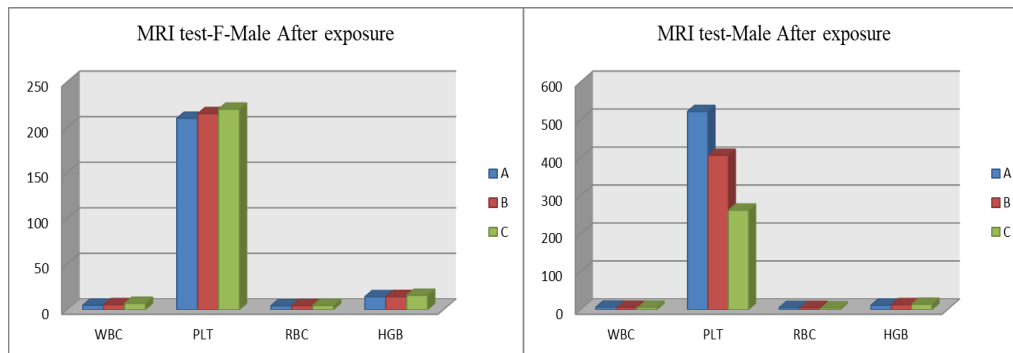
MRI test for Male & Female After exposures.
